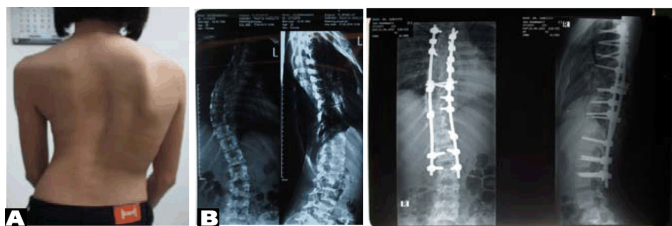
(A and B): Sixth patient case presentation: clinical picture pre-operative (A) and X-ray (B) pre- and post-operative.
